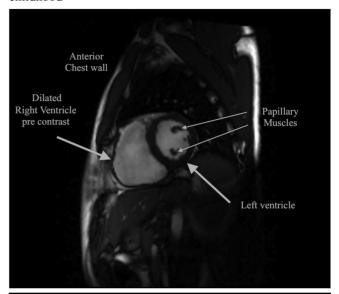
Short Axis Cardiac MRI images before and after Gadolinium contrast showing abnormal uptake at the RV apex and the anteroseptal region of the LV.
